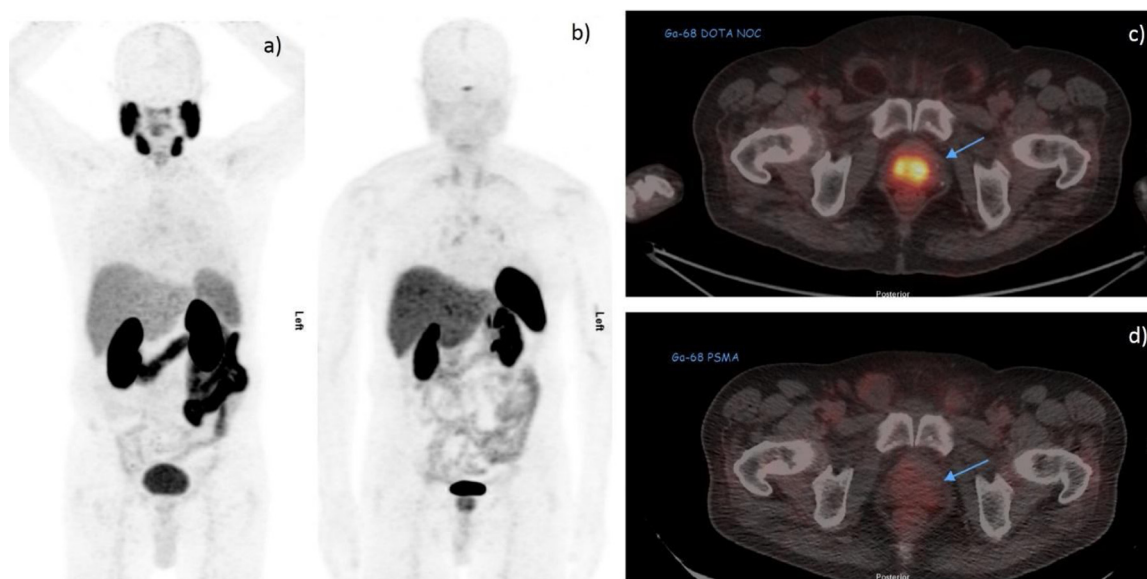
A-72-year-old gentleman is a case of metastatic prostate cancer on androgen deprivation therapy. (a) ^{68}Ga -PSMA scan. (b) ^{68}Ga -DOTANOC study. (c) Fused ^{68}Ga -DOTANOC. The prostate gland is enlarged with focal calcification and demonstrates diffusely intense increased radiotracer localization with SUVmax of 9.4. (d) Mild tracer uptake of SUV max 2.2 is seen at enlarged prostate. Prostate biopsy was performed showing neuroendocrine differentiation.
